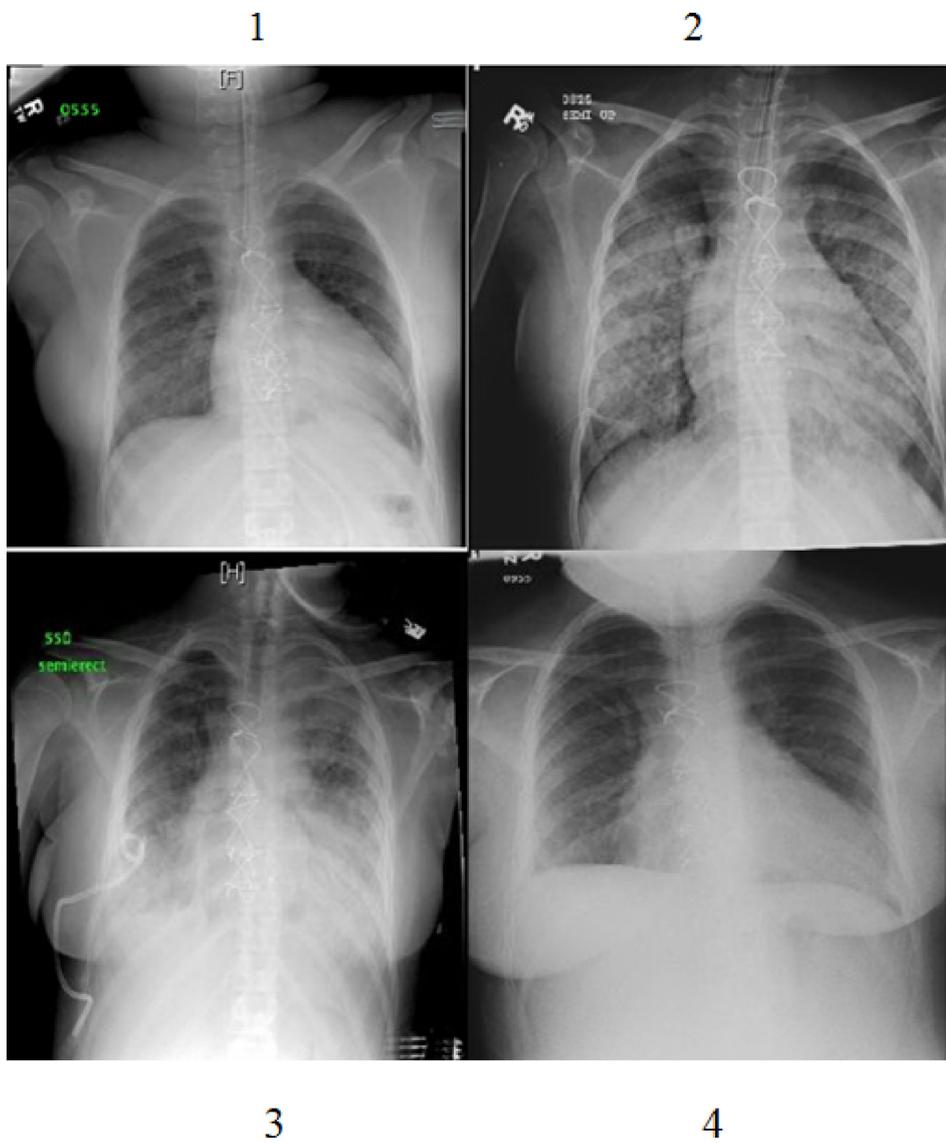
Serial chest x-ray imaging in Case #1.
